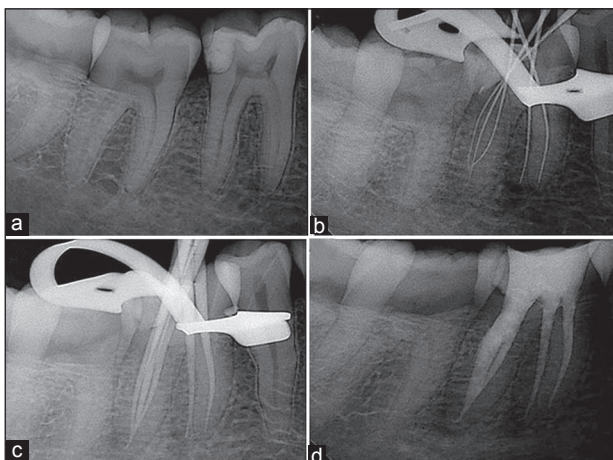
(a) Pre-operative radiograph of mandibular right first permanent molar (b) working length radiograph showing three distal canals merging in the apical third (c) master cone radiograph (d) post obturation radiograph
